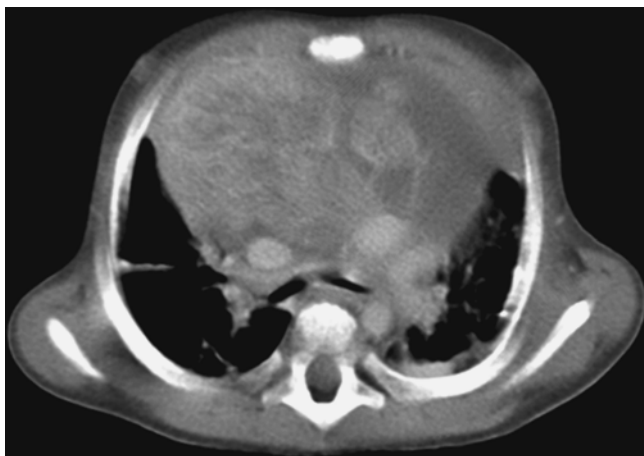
CT scan of a large mediastinal germ cell tumor with airway compromise
